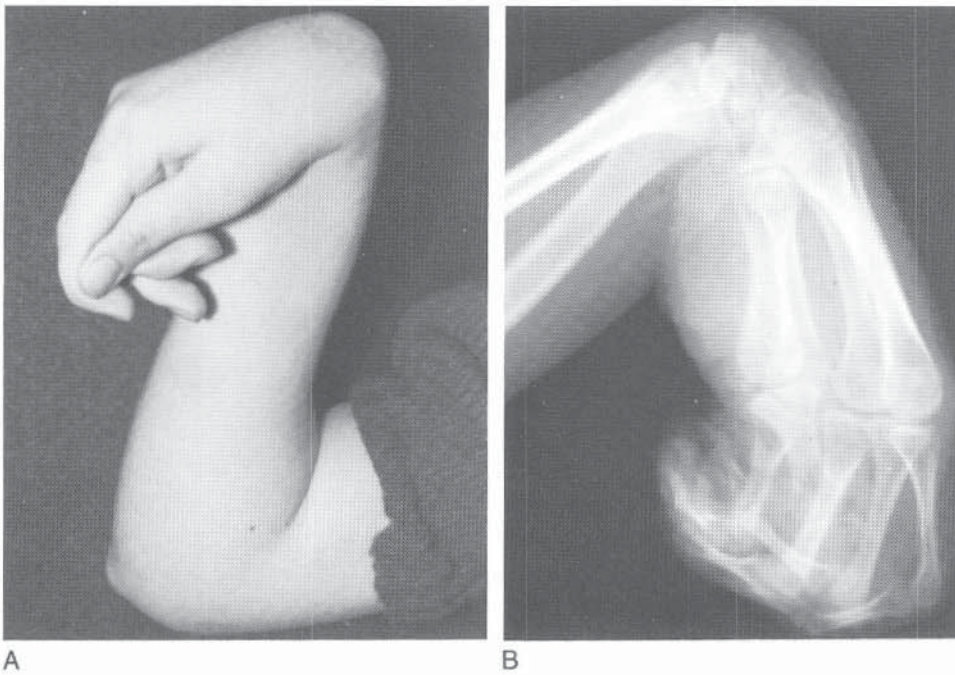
Acute flexed wrist and hand with pronation of the forearm in a child with cerebral palsy. A, The patient's upper limb. B, Lateral radiograph showing the volar subluxation of the carpus.
